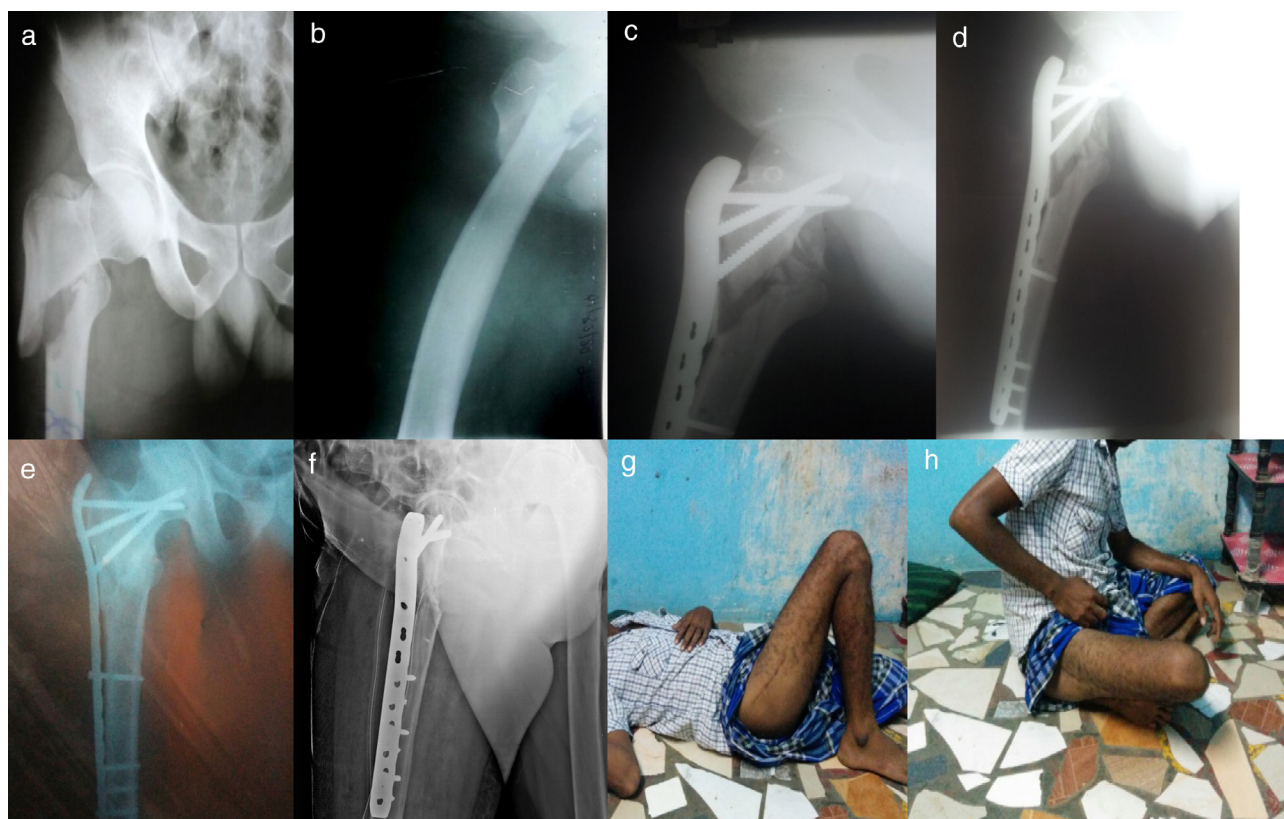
(a, b) Pre-operative X-rays of 36 year male with right complex proximal femoral fracture; (c, d) 3 month post-op X-rays after PF-LCP fixation showing delayed union and required additional bone grafting; (e, f) X-rays showing good fracture union at end of one year; (g, h) clinical picture showing fair functional outcome and Parker-Palmar mobility score of 7.7 for the patient.
